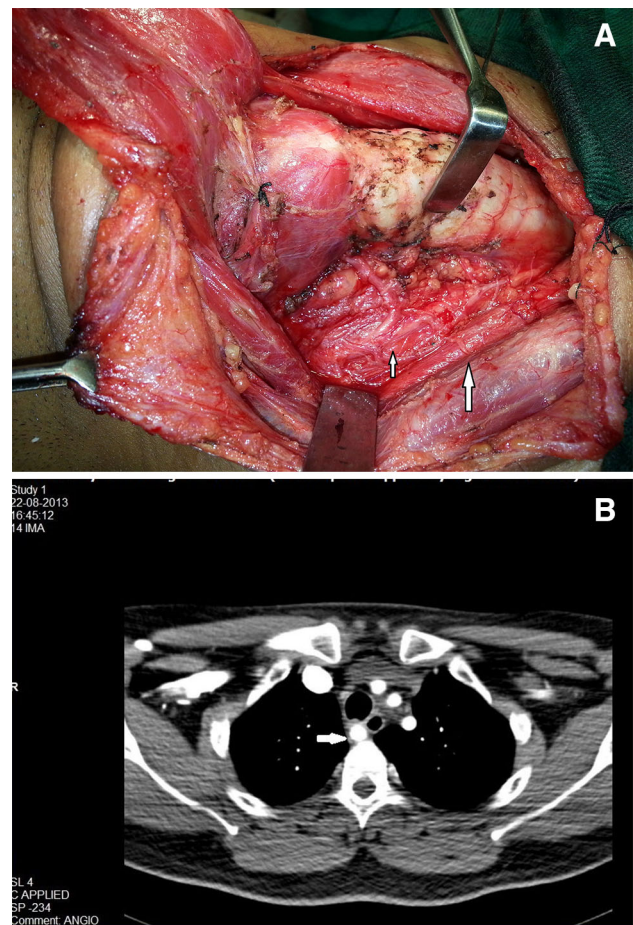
a (Case 2) Intraoperative photograph of a medially placed right vagus nerve in relation to CCA with type II NRLN (*small arrow* vagus nerve with NRLN, *big arrow* CCA). b (Case 2) Postoperative CT scan demonstrating a right aberrant subclavian artery (*arrow*)
